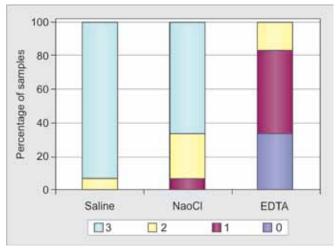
Smear layer removal after root canal instrumentation with use of Ultrasonic for the activation of irrigants
